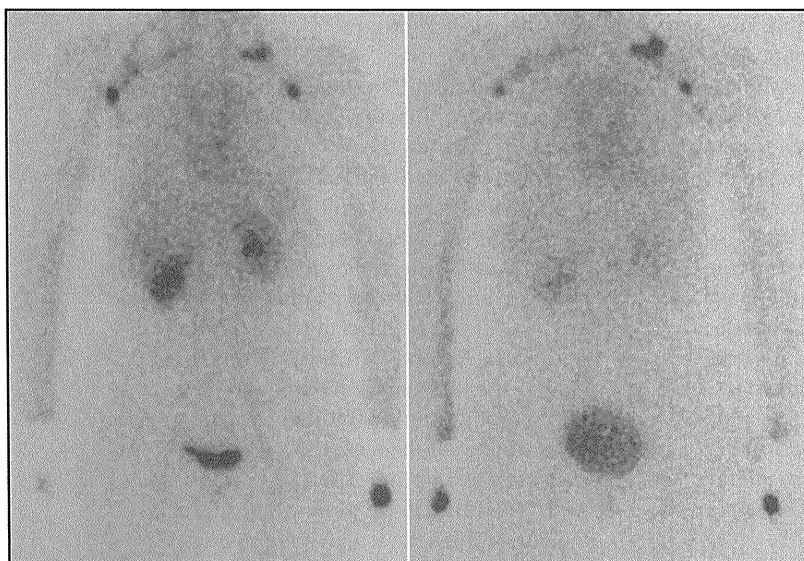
Lymphoscintigraphy images of a case of Type I-Subtype E lymphedema in the left arm. The left and right panels show images taken 30 and 120 min, respectively, after injection of a contrast medium. Lymph nodes around the clavicle, but not axillary lymph nodes, were observed in the affected left arm. Dermal back flow (DBF) was confirmed to be absent in both arms.
